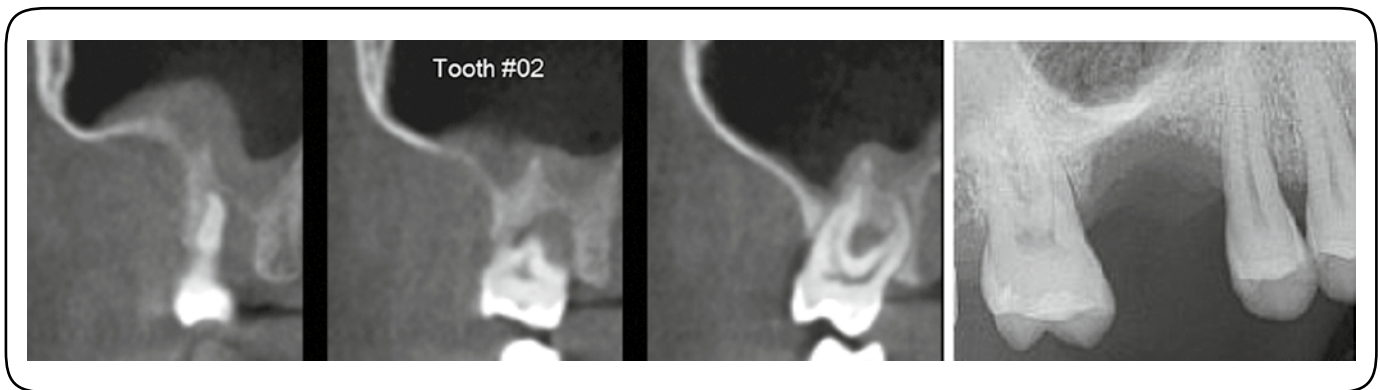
Comparison of cross-sections from CBCT and periapical radiographs: angular bone loss of tooth #2.
